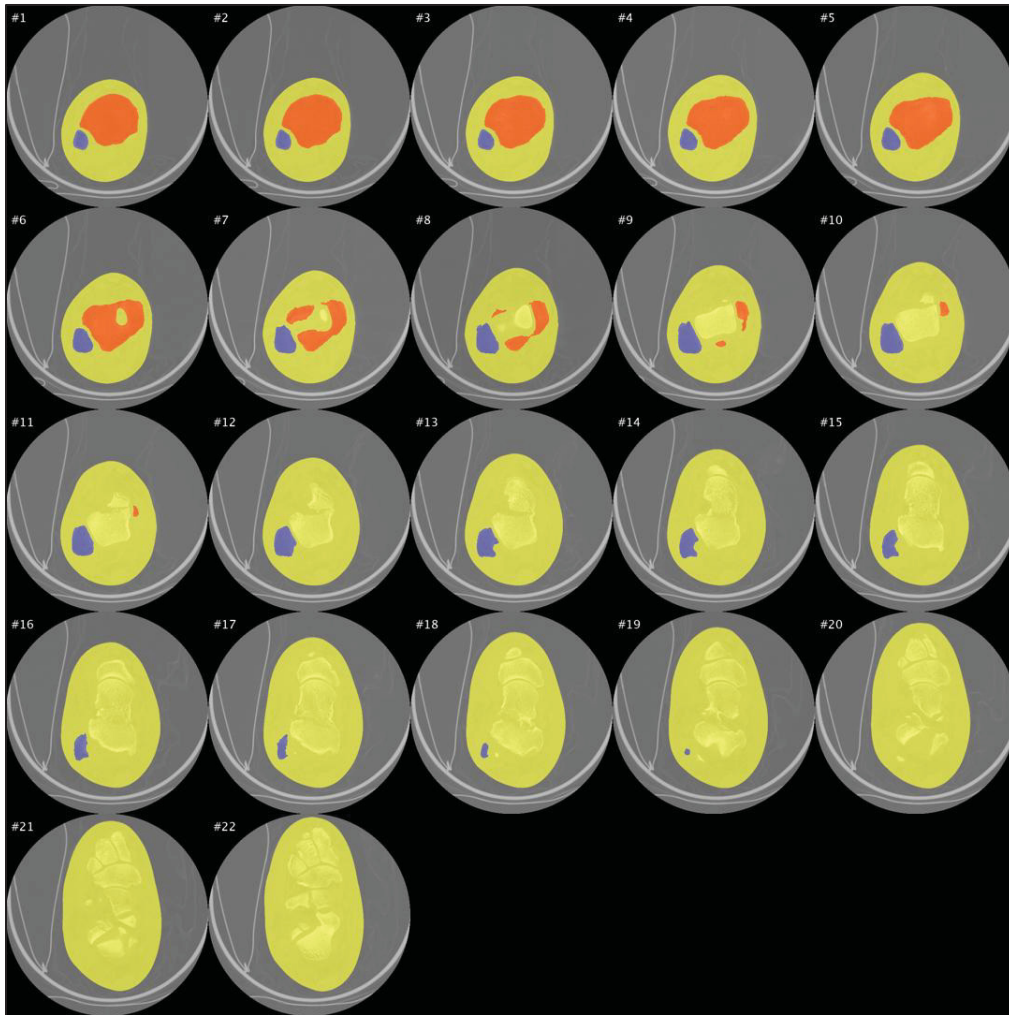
multi-class segmented CT slices, indicating tibia (in red), fibula (in blue) and ankle and foot (in yellow)
